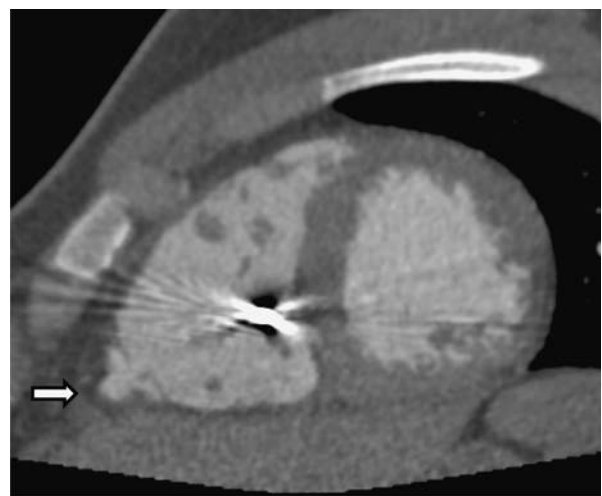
Right ventricular basal aneurysm demonstrated on reformatted CT images in a patient with sustained ventricular tachycardia.
